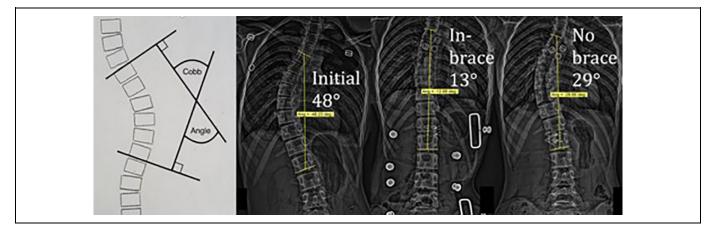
First: Cobb angle of measurement; second to fourth: AP radiographs showing an initial 48° scoliosis (T5-L1) in a 14-year old female which reduced to 13° with the patient wearing a rigid corrective brace; after 3 months, a 19° reduction occurred as a follow-up, out-of-brace image showed a 29° curvature as measured from the same vertebral levels as the initial. This patient is still under treatment by the first author. AP indicates anteroposterior.
